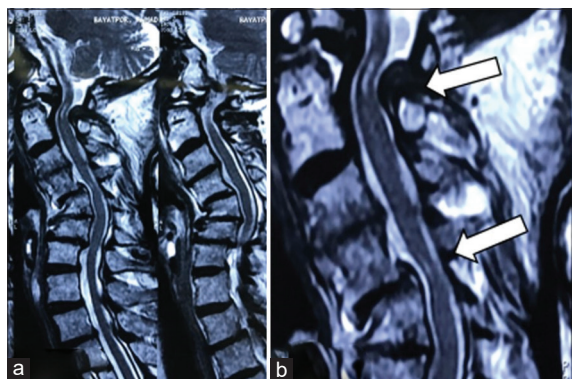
Magnetic resonance imaging (a) demonstrates cervical myelopathy and posteriorly displaced os odontoideum (b) note two myelopathy patches one at upper and one at mid-cervical region.
